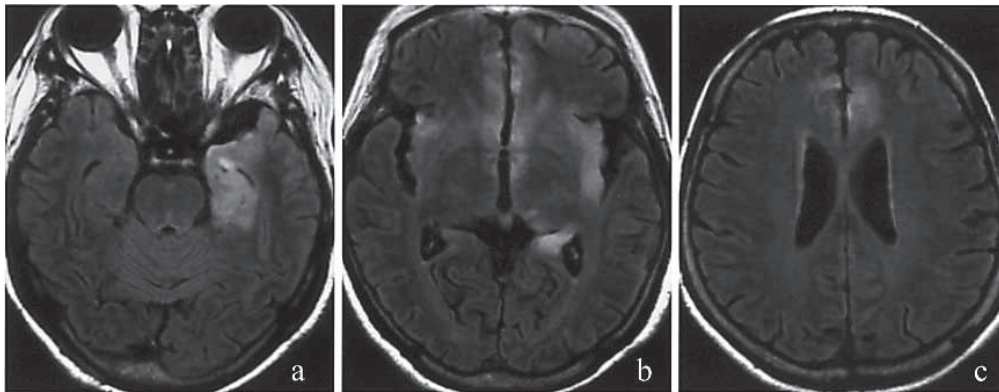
(a–c) FLAIR images at 35 days after onset showed hyperintense signals in bilateral cingulate gyri, insular cortices and left medial temporal lobe.
